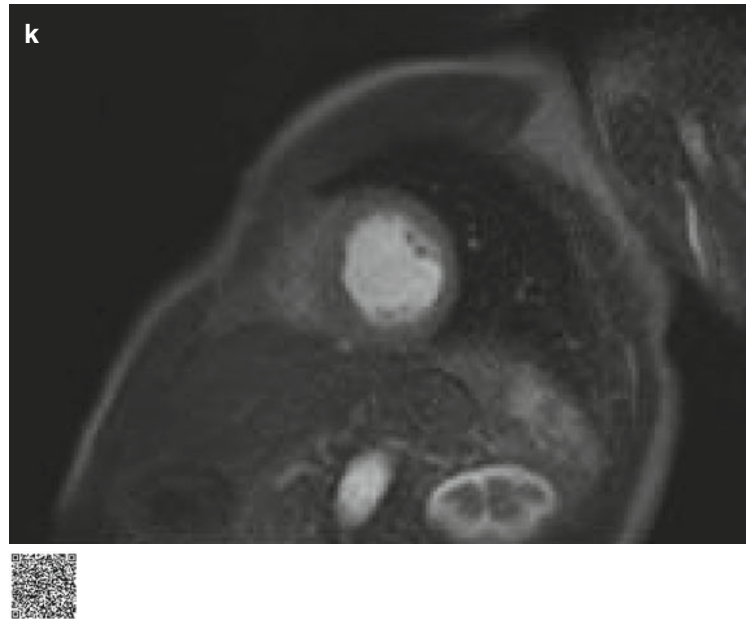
Stress perfusion MRI shows a ring of subendocardial perfusion defect on the entire basal wall (a, b). However, rest perfusion
